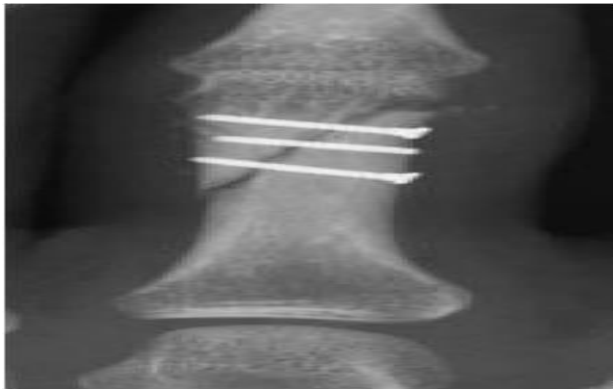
2 weeks post-operative AP radiograph demonstrating maintained reduction.
